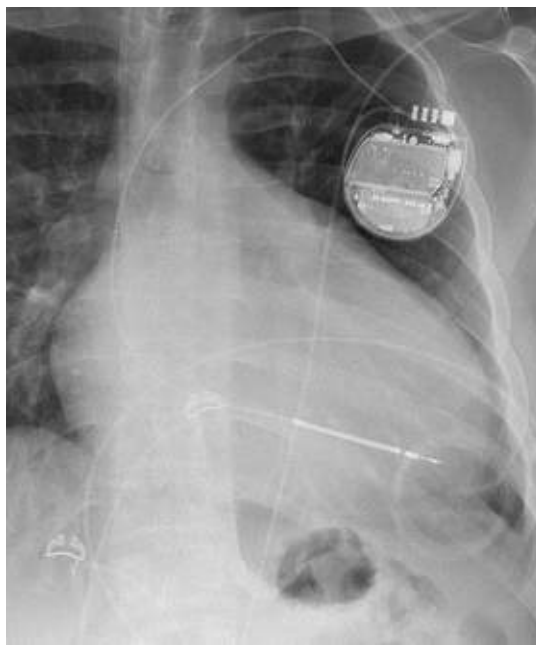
Left ventricle enlargement. Cone-down PA chest radiograph of 20-year-old man with severe nonischemic cardiomyopathy shows an extremely large left ventricle with the cardiac apex displaced toward the left. The patient also had pulmonary hypertension with an enlarged contour of the main pulmonary artery.
